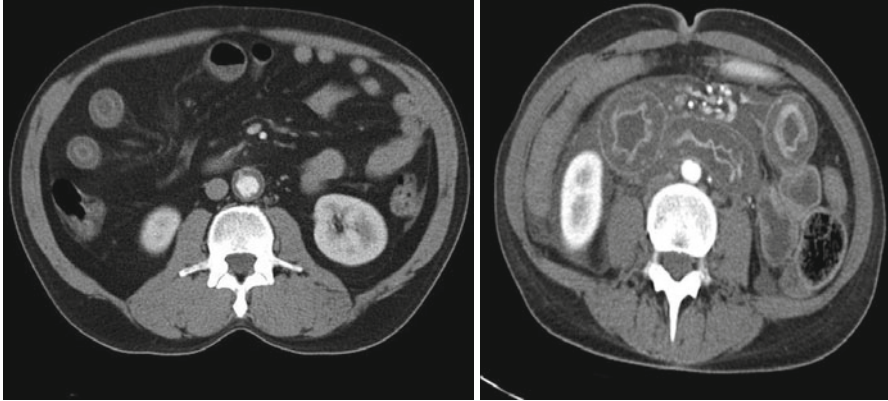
CT images obtained during intravenous contrast enhancement show concentric rings of high and low attenuation of the bowel wall – the target sign – a feature seen in ischemic bowel
